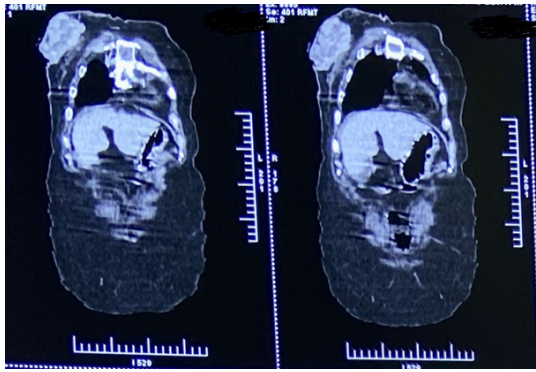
Coronal view of a large lobulated mass lesion in the right breast in Contrast enhanced CT chest.
